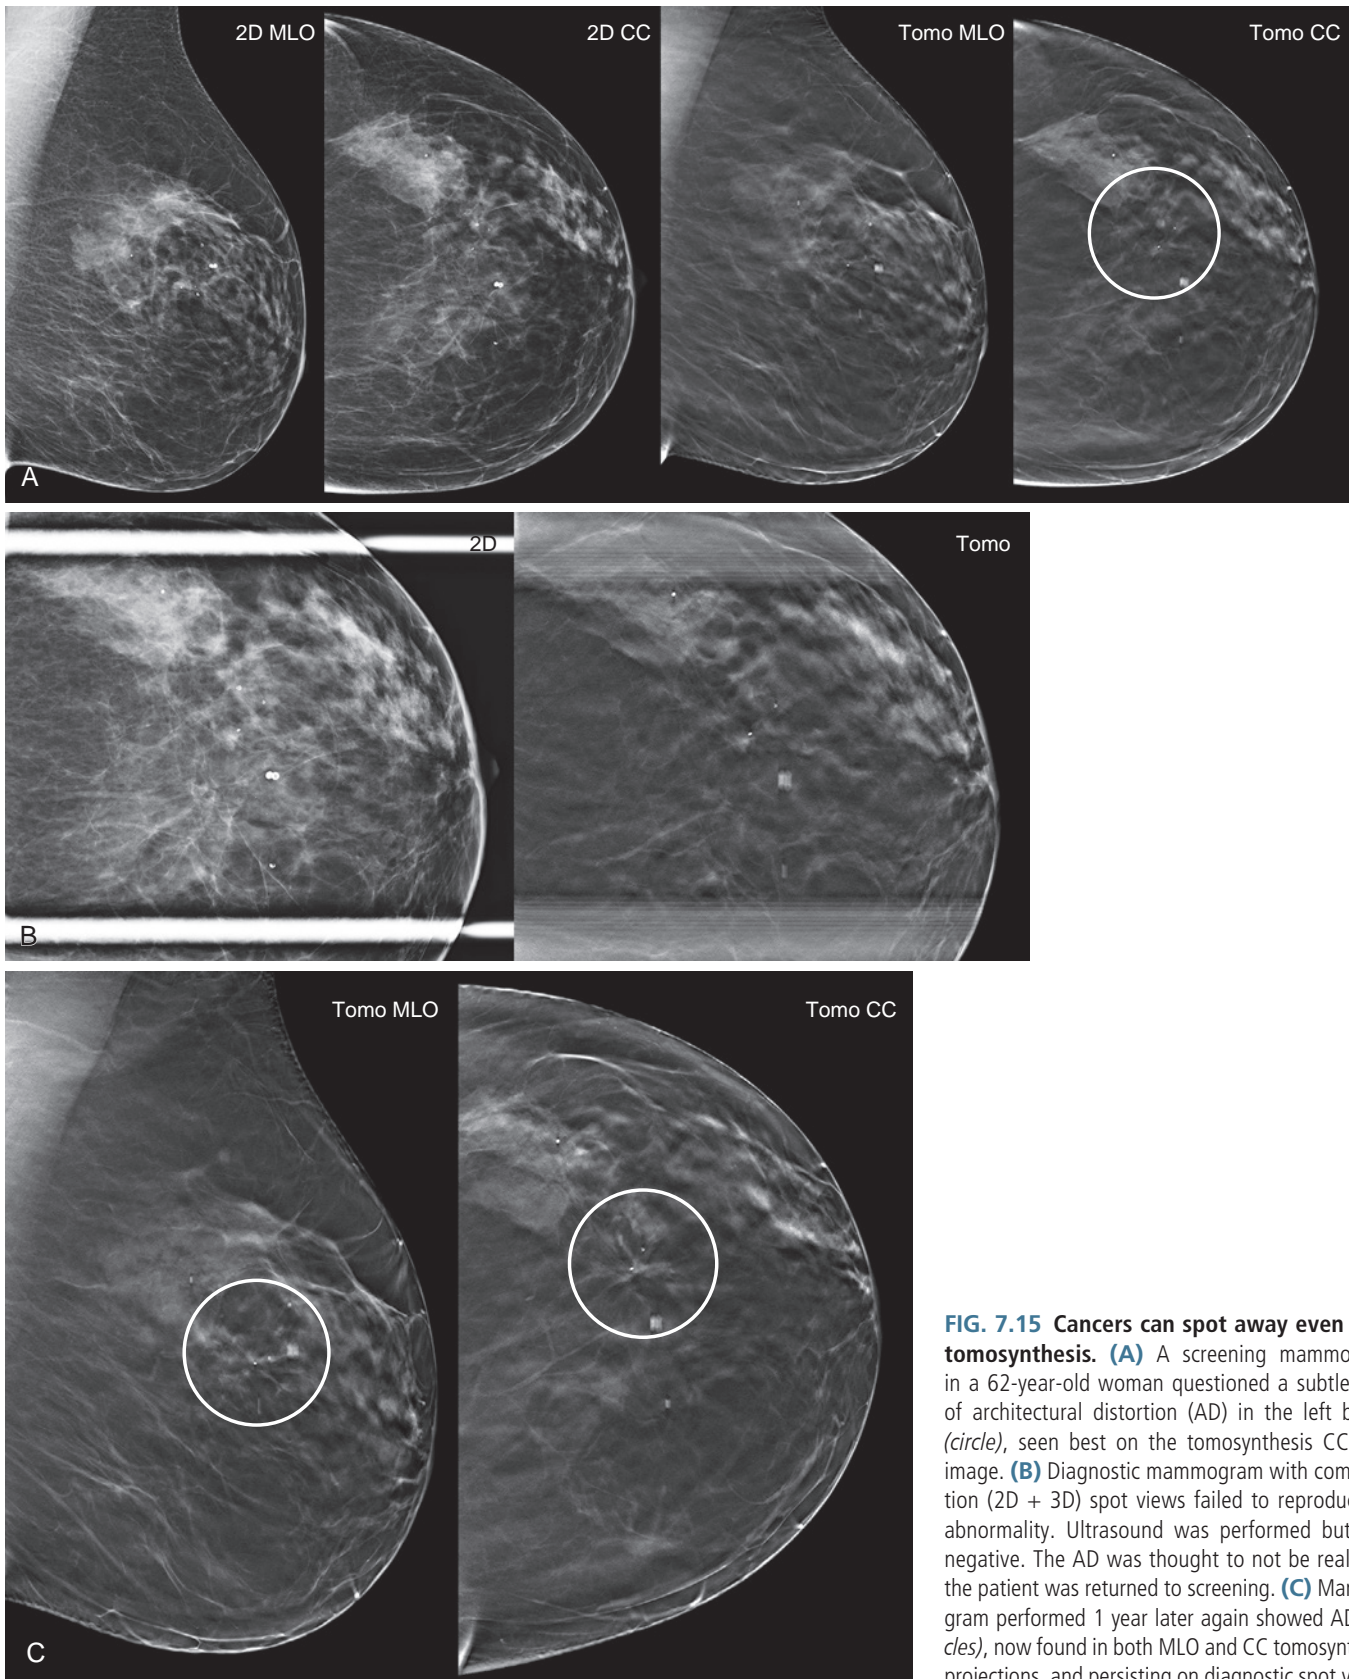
Cancers can spot away even with tomosynthesis. (A) A screening mammogram in a 62-year-old woman questioned a subtle area of architectural distortion (AD) in the left breast (*circle*), seen best on the tomosynthesis CC slice image. (B) Diagnostic mammogram with combination (2D + 3D) spot views failed to reproduce an abnormality. Ultrasound was performed but was negative. The AD was thought to not be real, and the patient was returned to screening. (C) Mammogram performed 1 year later again showed AD (*circles*), now found in both MLO and CC tomosynthesis projections, and persisting on diagnostic spot views.
